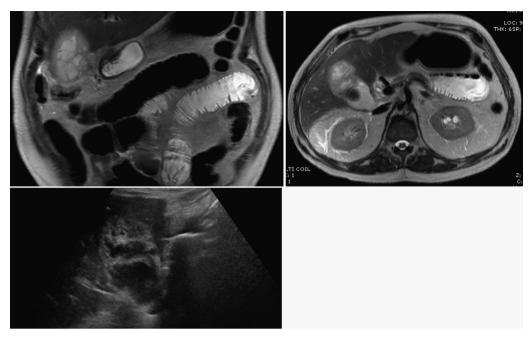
Left to right: MRCP and ultrasound imaging from Mr. GW. #1 and #2: MRCP showing thickened gallbladder wall, lack of wall enhancement and septated surface with diffuse inflammation. #3: Ultrasound showing thickened wall, maximally dilated at 1.2 cm with multiple septations.
